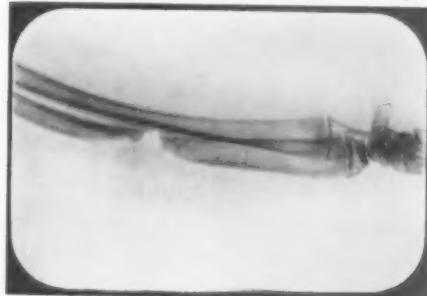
Experiment 10. Seven days after operation. Into the hiatus in the shaft was injected one cubic centimetre of five per cent. solution triple calcium phosphate, six days before this radiograph was taken. Note that the ends of the shaft fragments are already beginning to close in. There is some callus formation in the soft parts about the lesion.
